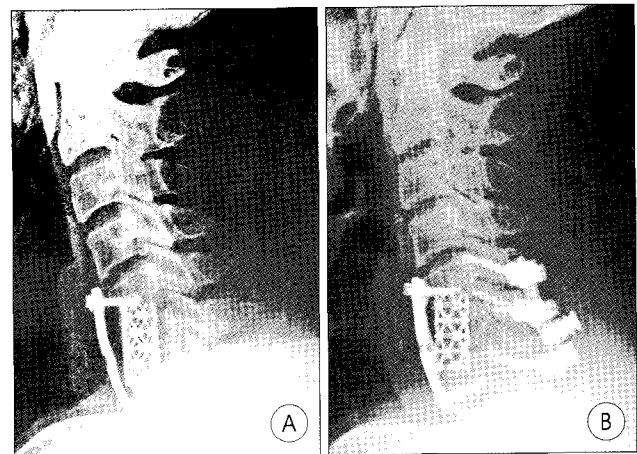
A : Lateral radiograph of failure of a 1-level corpectomy reconstruction using a 13-mm titanium mesh cage 4.5 months after surgery for cervical myelopathy. The plate had pulled out of the cephalad part of the vertebral body. B : Lateral radiograph 6 months after the revision surgery demonstrating a successful fusion with only posterior lateral mass screw-rod fixation.
